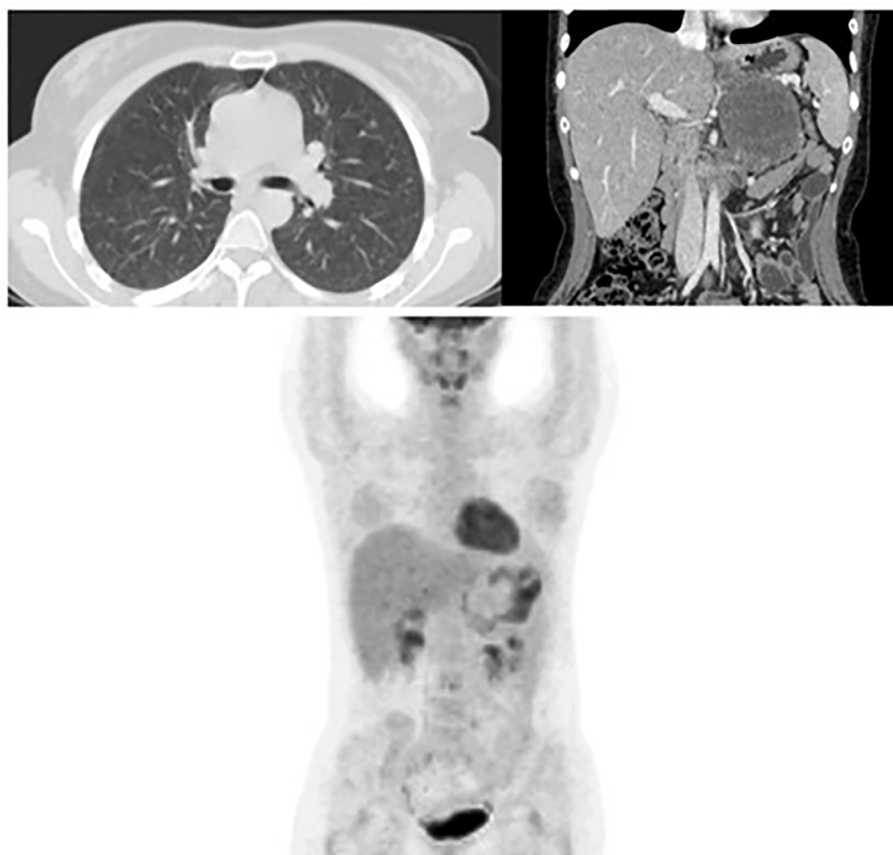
Multiple pulmonary metastases and adrenal mass detected by CT Scan (January 2020).
